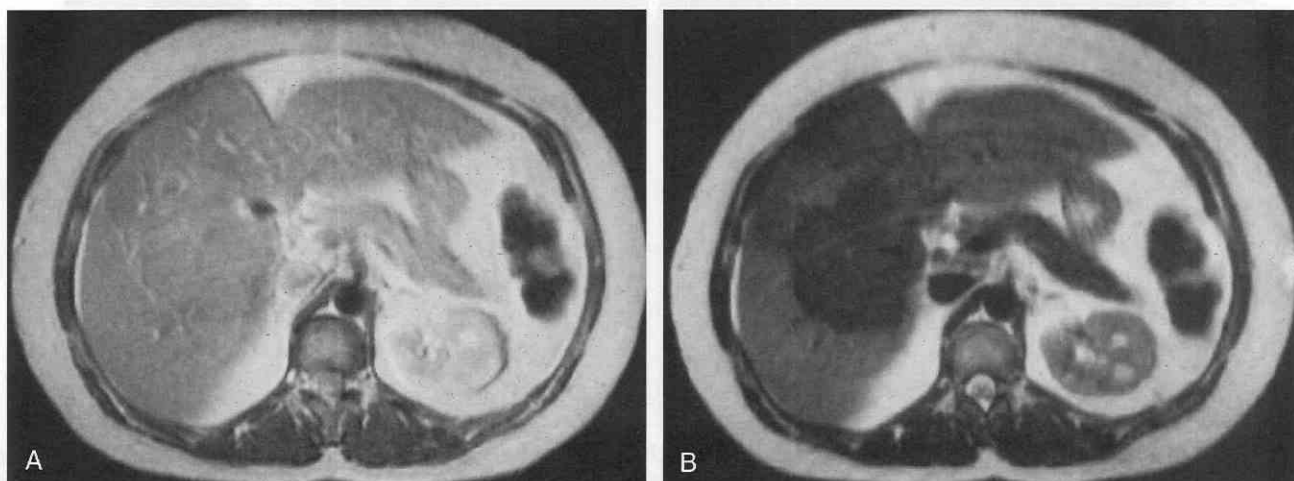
Focal nodular hyperplasia. *A*, Unenhanced T2-weighted image demonstrates a large lesion in the right hepatic lobe. *B*, T2-weighted image after superparamagnetic iron oxide (USPIO) administration demonstrates signal loss.
